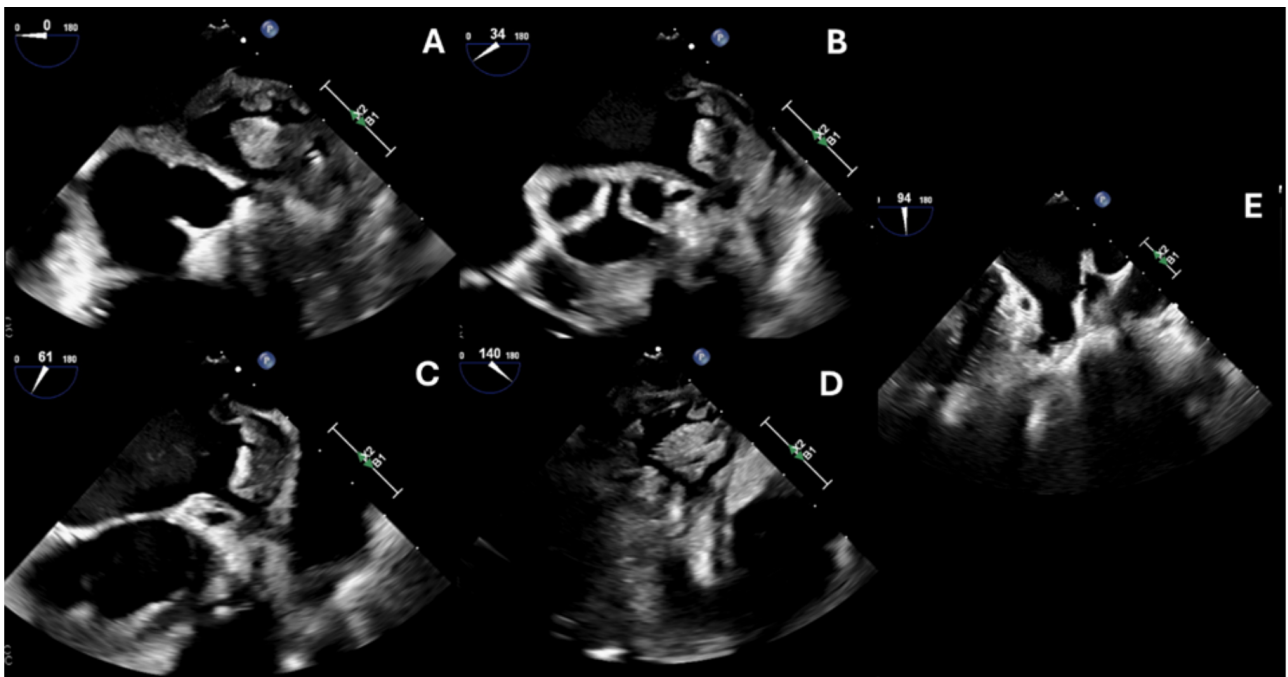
LAA thrombus on trans-esophageal echocardiogram. (A) LAA and LAA thrombus at 0 degrees. (B) LAA and LAA thrombus at 34 degrees. (C) Similar findings at 61 degrees. (D) LAA thrombus at 140 degrees of TEE. (E) (A–D) shows LAA thrombus and this is in stark contrast to (E) which is a different patient with no LAA thrombus.
